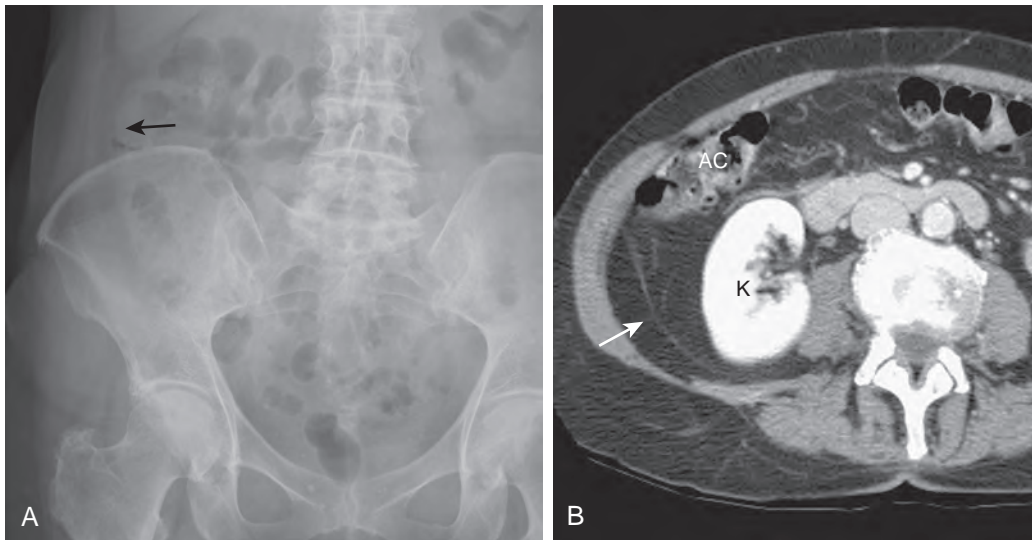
Lateroconal fascia. A. Supine abdominal radiograph shows the lateroconal fascia (arrow) along the paracolic gutter as a thin white line extending from the liver tip to the right lower quadrant. B. Axial CT scan shows the lateroconal fascia (arrow), which is composed of the anterior and posterior layers of the perirenal fascia that fuse laterally. The ascending colon (AC) is contained within the anterior pararenal space. K, kidney.
